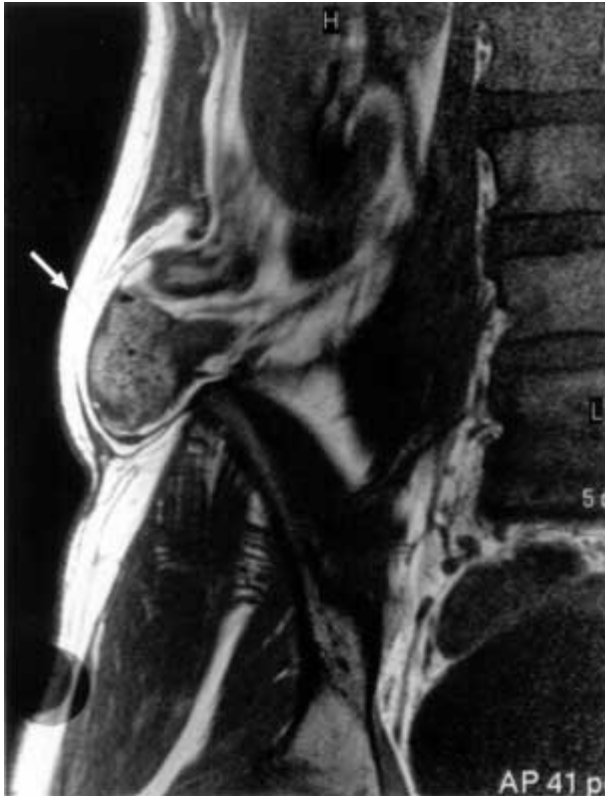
MRI 4 months postinjury, frontal view
